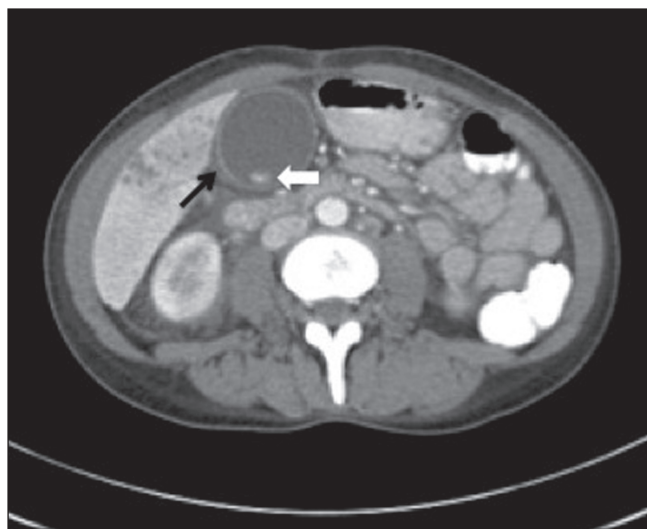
Enhanced computed tomography of the abdomen showing an enlarged gallbladder with sludge and a solitary stone measuring 1.2 cm (white arrow). Pericholecystic fluid is also present (black arrow)
